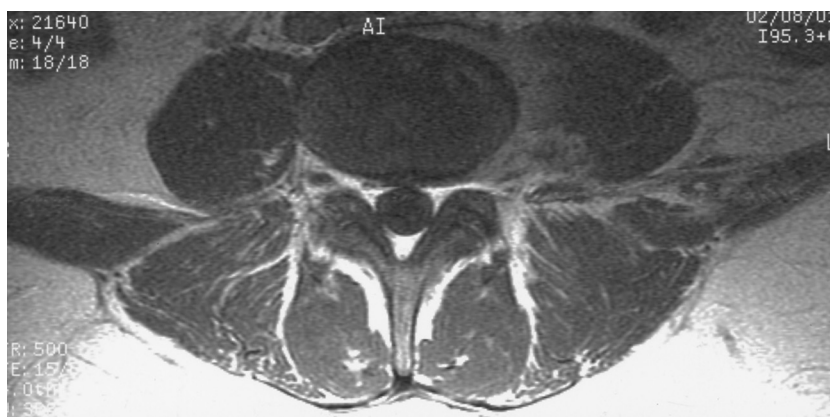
Computed tomography scan of the chest showing voluminous psoas abscess.
